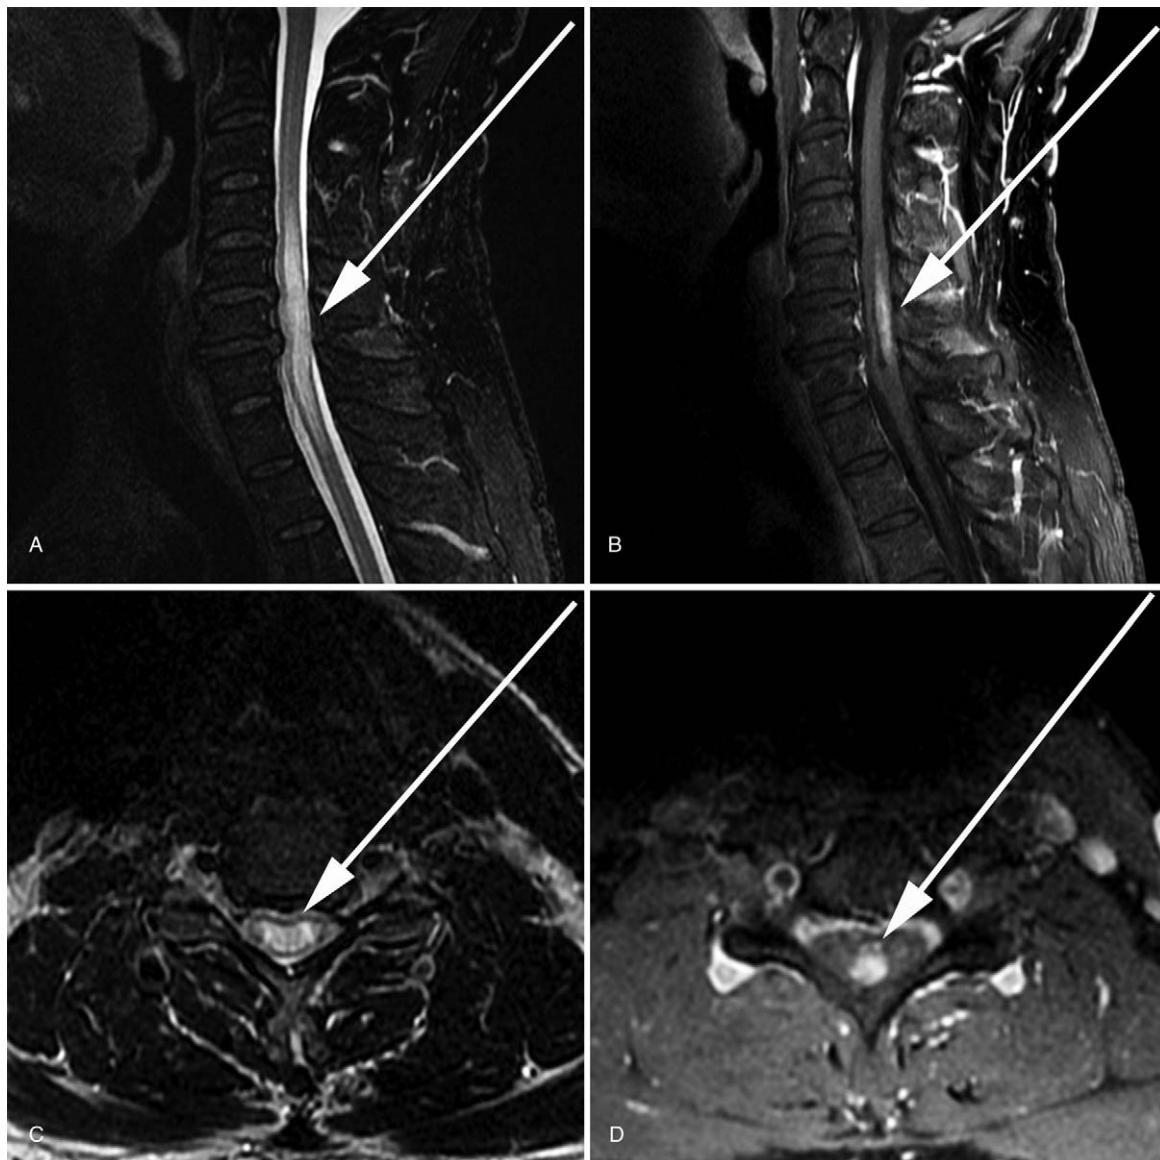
A 46-year-old man who presented with numbness and tingling of the bilateral fourth and fifth fingers. MRI of the spine revealed a T2 hyperintense abnormality with cord distension centered at the C6 vertebral body level (A and C). A disc protrusion at the C6-7 disc level (A, white arrow) was not felt an adequate explanation for the findings. Postcontrast imaging (B and D) revealed a relatively well-defined area of enhancement involving the central cord. FDG PET CT right posterior oblique projection MIP image of the chest (E) displays bilateral hypermetabolic hilar lymph nodes. (F) One-hour post-FDG injection PET imaging displays hypermetabolism corresponding to the area of abnormal cord enhancement with a maximum SUV of 6.1. The degree of hypermetabolism increases on 5-hour postinjection imaging compared with the normal appearing spinal cord. The maximum SUV at this time was 6.4 (G).
